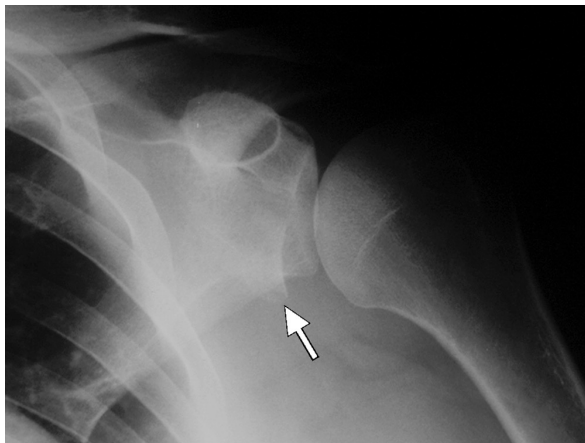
True anteroposterior plain radiograph demonstrating an antero-inferior glenoid fracture (arrow). (From Browner BD, Levine AM, Jupiter JB, et al: *Skeletal trauma*, ed 4, Philadelphia, 2009, Saunders.)
